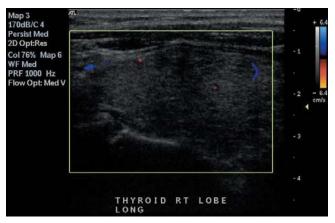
Longitudinal image of the right thyroid lobe showing decrease vascularity on power Doppler within a normal thyroid gland typical of Type II AIT
